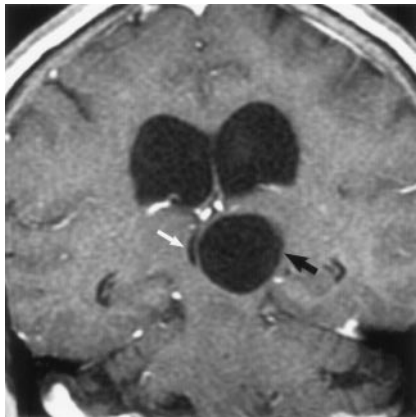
Coronal postcontrast T1-weighted image obtained in a 56-year-old woman with headaches shows a nonenhancing unilocular giant perivascular space (black arrow) in the left thalamus with compression and displacement of the third ventricle (white arrow). Note associated hydrocephalus. Surgery disclosed a smooth walled cyst with no abnormality in the adjacent brain. The patient initially underwent a cyst fenestration with a decrease in the size of the PVS. Four months later, there was reaccumulation of fluid and the PVS enlarged to its original size. A ventriculoperitoneal shunt was then placed, which relieved the hydrocephalus. Follow-up studies showed no change in cyst size over 4 years.
